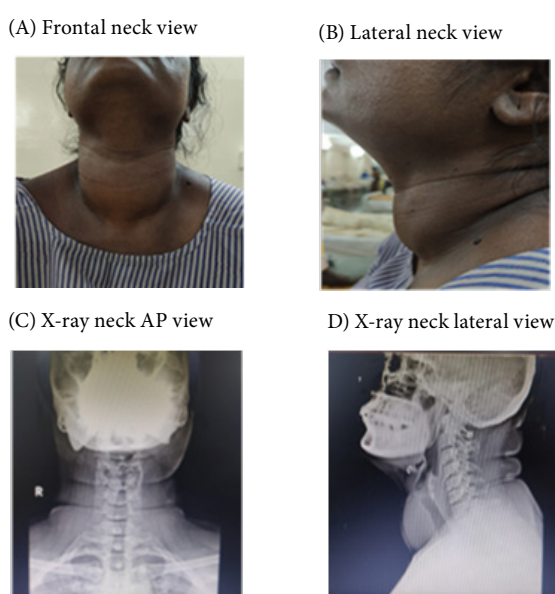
(A) Frontal and (B) lateral clinical photographs showing anterior neck swelling in case 2. (C) Anteroposterior (AP) and (D) lateral neck radiographs demonstrating an enlarged thyroid gland without significant tracheal compression or deviation.
